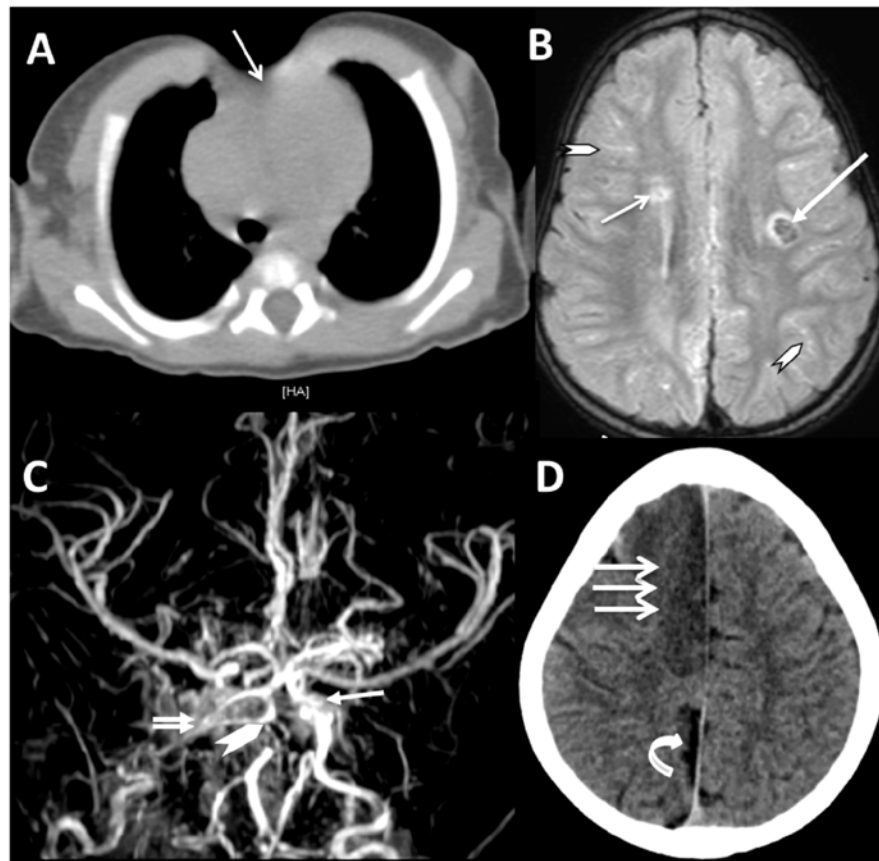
Noncontrast CT thorax (A) shows the sternal cleft (arrow in A). FLAIR axial image (B) of the brain, above the level of the ventricles, showing ischemic changes and lacunar infarcts in the centrum semiovale on both sides (arrows in B). FLAIR sulcal hyperintensity (chevrons in B) is seen due to slow flow in the leptomeningeal collaterals. MR angiogram (C) shows occlusion of right ICA (double arrows show the expected location of right ICA which is not seen as it is occluded), stenosis of terminal left ICA (arrow in C) and occlusion of basilar artery (chevron in C). ‘Puff of smoke’ is the increased multiple fine linear opacities seen around the circle of Willis. Axial non-contrast CT of the brain (D), at age of 4years, in supraventricular region, showing a subacute infarct in right ACA territory (triple arrows in D) and old infarct in right parietal parasagittal region (curved arrow in D).
